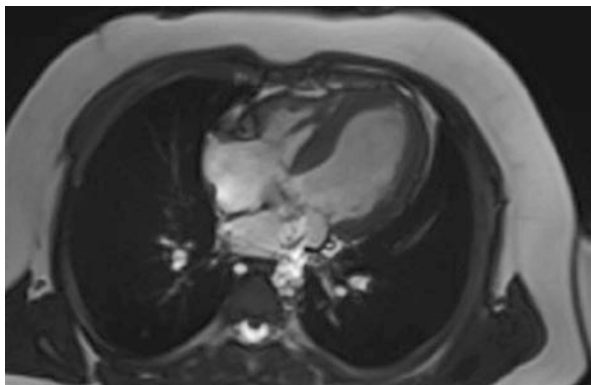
MRI image in the same patient which confirms the echocardiographic findings
